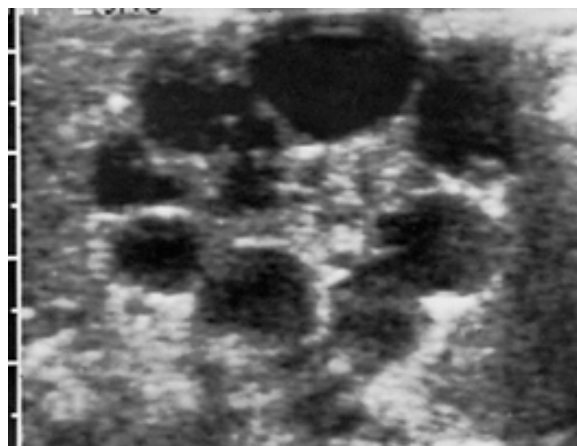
Multicystic kidney disease in female newborn. Renal ultrasonography at 1 week of age reveals multiple cysts in the right flank with septation between the cysts but no normal renal parenchyma. No communication was identified between the cysts, as would be present with hydronephrosis. The left kidney (not shown) was found to have ureteropelvic junction obstruction.
